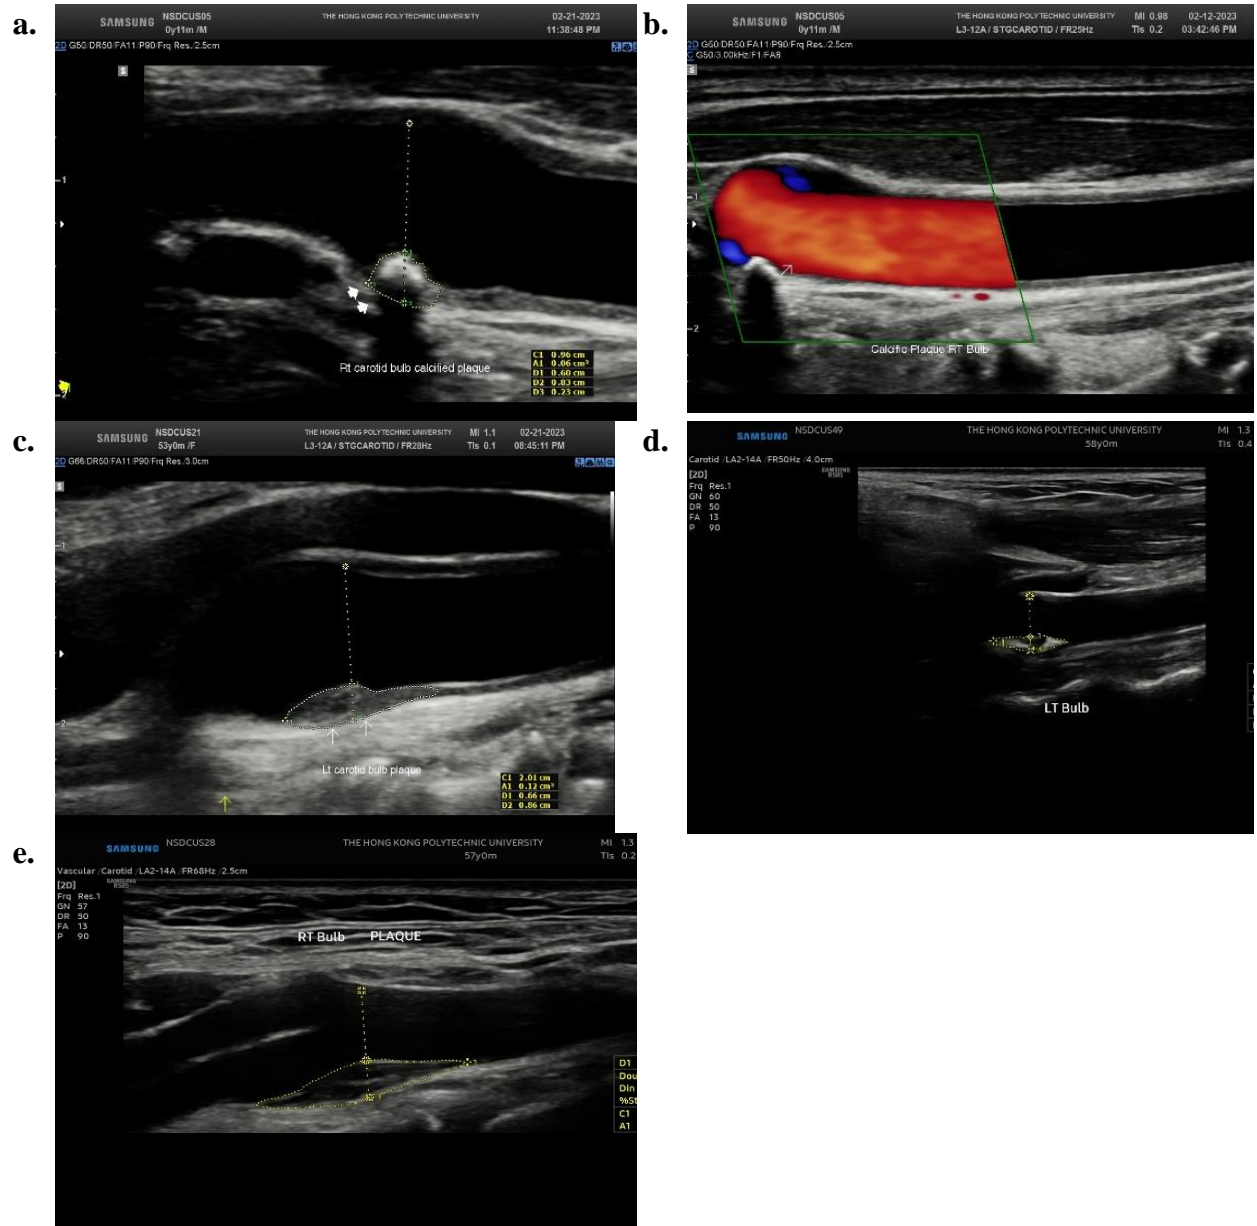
(a-e): a.) Longitudinal section of the RT carotid bulb showing a calcified plaque with posterior shadowing in one of the subjects with posterior shadowing. b.) color doppler showing a
